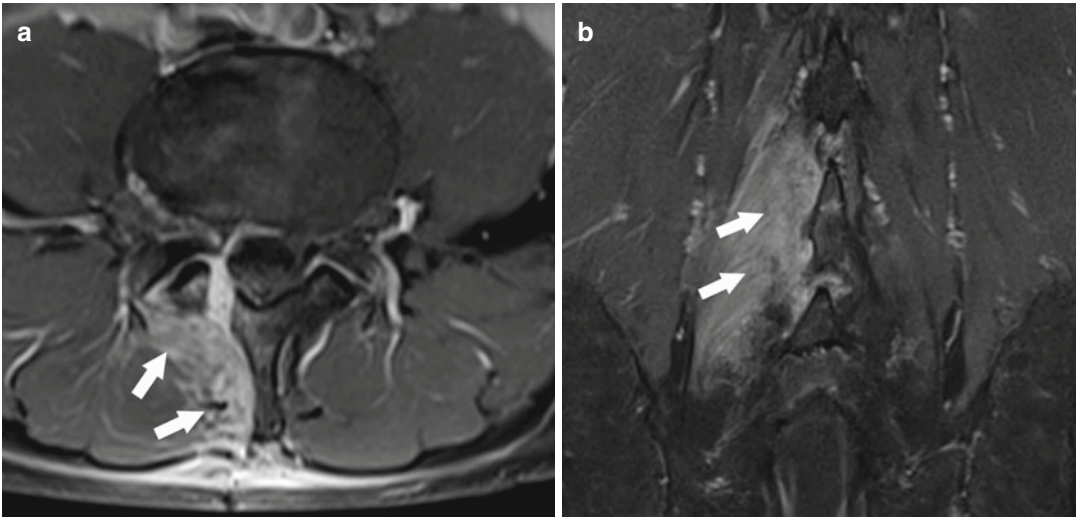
Back pain after disk surgery. Axial gadolinium-enhanced T1w MR image (a) and coronal fatsat T2w image (b) demonstrate multifidus edema consistent with postoperative denervation (arrow)
